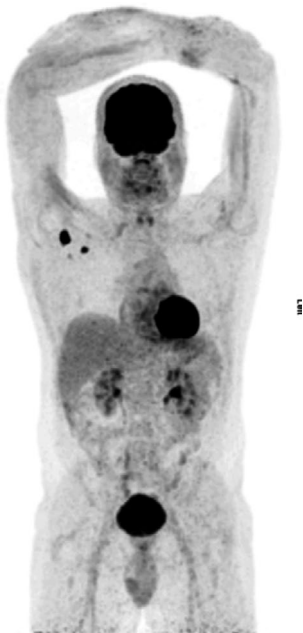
PET-CT scan showing lymphedema of the right arm and localized FDG avidity in the right axilla
